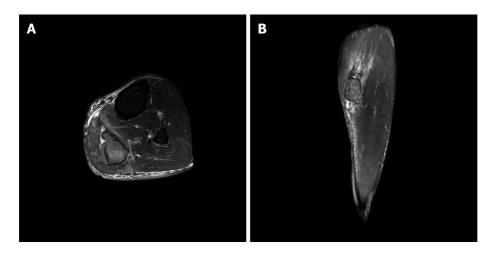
Magnetic resonance images of the hematoma in the left gastrocnemius muscle. A: Axial view; B: Longitudinal view.
